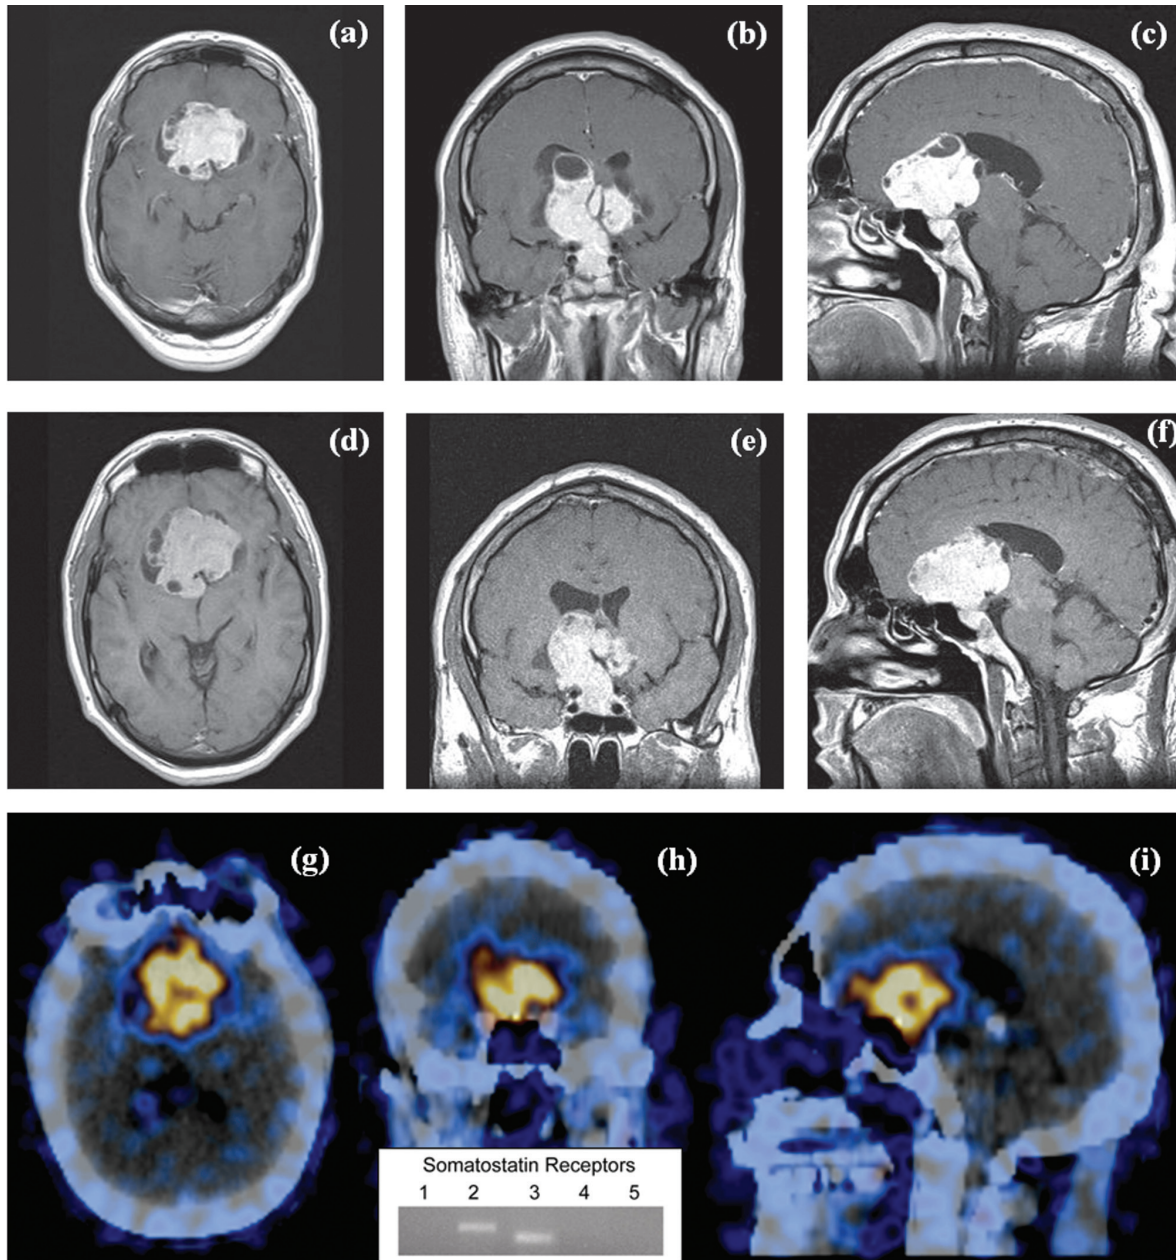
Gadolinium-enhanced T1-weighted MRI images: axial (a), coronal (b) and sagittal (c) views obtained at diagnosis; axial (d), coronal (e) and sagittal (f) MRI scan performed 4 months after medical therapy. ^{111}In -pentetreotide (Octreoscan) SPET/CT: fused transaxial (g), coronal (h) and sagittal (i) images. In the box: PCR expression of somatostatin receptors 2 and 3.
